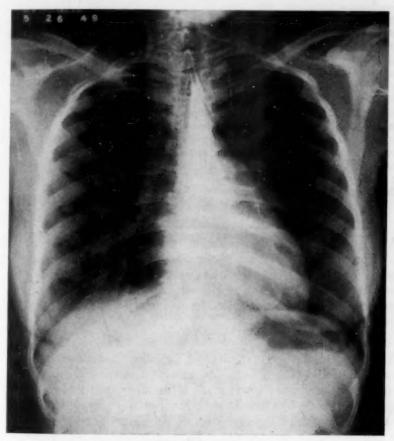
X-ray of the chest in case 5 reveals a prominence of the pulmonary artery.
